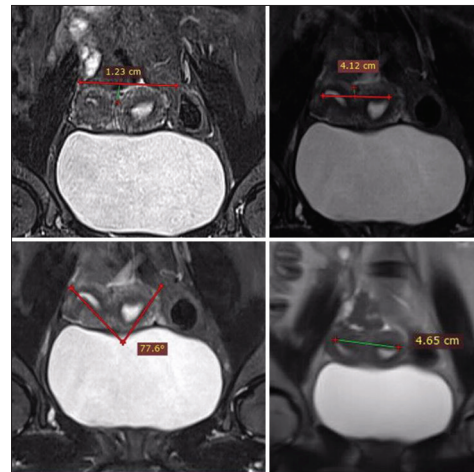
Magnetic resonance imaging pelvis showing different measurements used in the case described to prove it as bicornuate uterus
